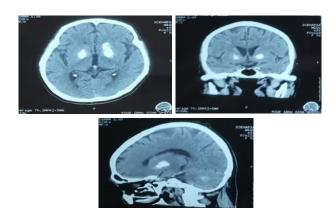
Brain CT Scan Examination
